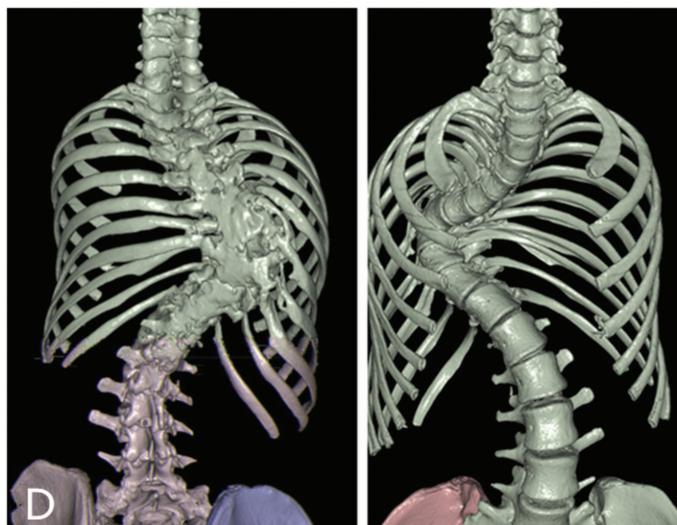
Three dimensional-computed tomography scans showed posterior spinal fusion.
